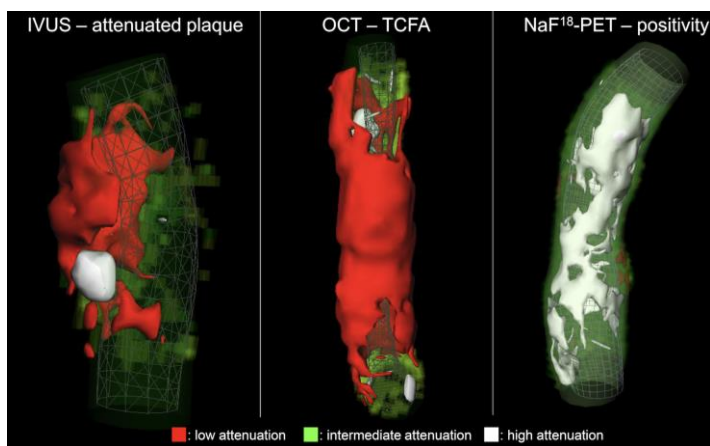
Representative volume rendered CT images of three coronary plaques corresponding to specific invasive and radionuclide imaging markers of plaque vulnerability.
